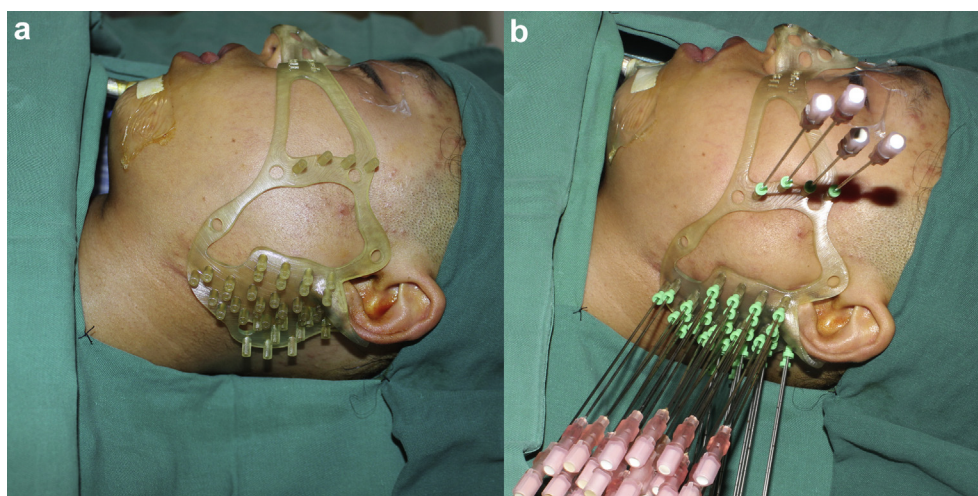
The individual template made through rapid prototyping technique contained all the information of preplan including needle pathway and face features simultaneously (a). Hollow interstitial needles were inserted into the target area from different directions to avoid bone, major blood vessels, and vital organs, and ^{125}I radioactive seeds were implanted permanently according to the plan with individual template and CT guidance (b).
